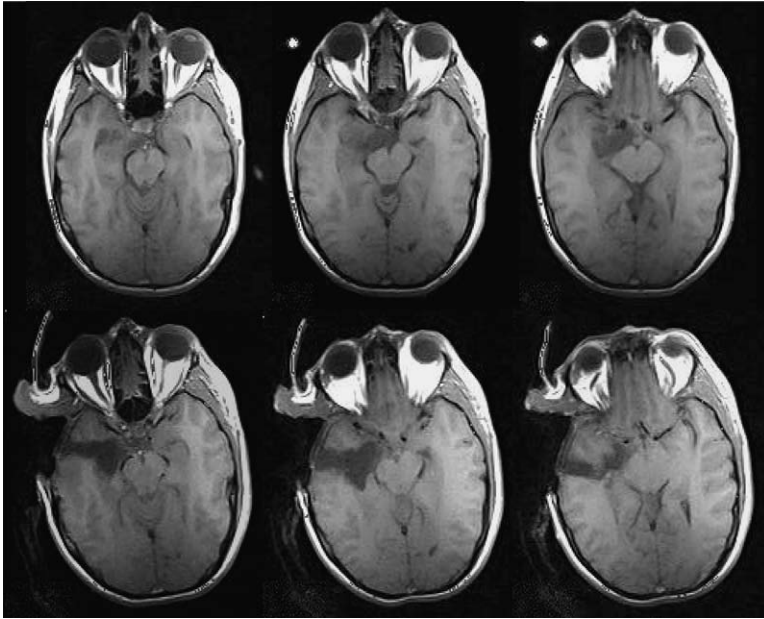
Surgical planning (*upper row*) and interdissection (*lower row*) T1-weighted MRI scans from a patient with a dysembryoplastic neuroepithelial tumor of the right mesial temporal lobe causing intractable epilepsy. The surgical planning study demonstrates the hypointense lesion. The interdissection study demonstrates complete resection of the lesion.
